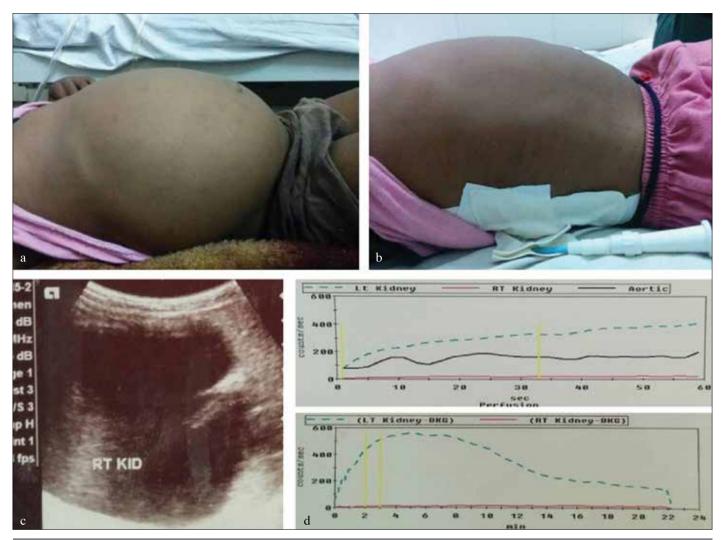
a-d. Young child presenting with distended abdomen and lump with difficult breathing (a). Immediate after percutaneous nephrostomy (PCN) tube placement, distension was relieved and patient improved symptomatically (b). Ultrasonography showing hugely dilated sac of the right kidney (c). Renal scan showing non- functioning right kidney (d)
